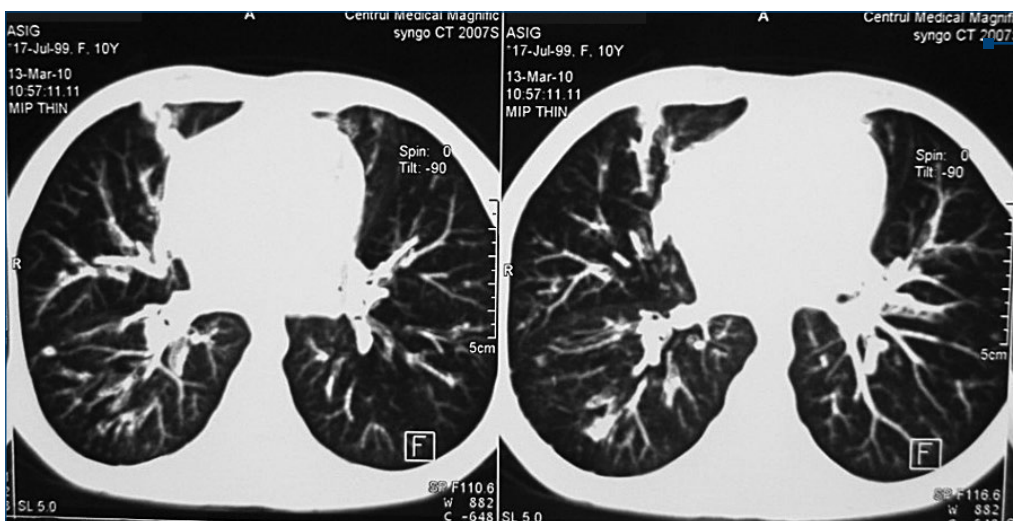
Patients CT scan (female, 15 years old)
